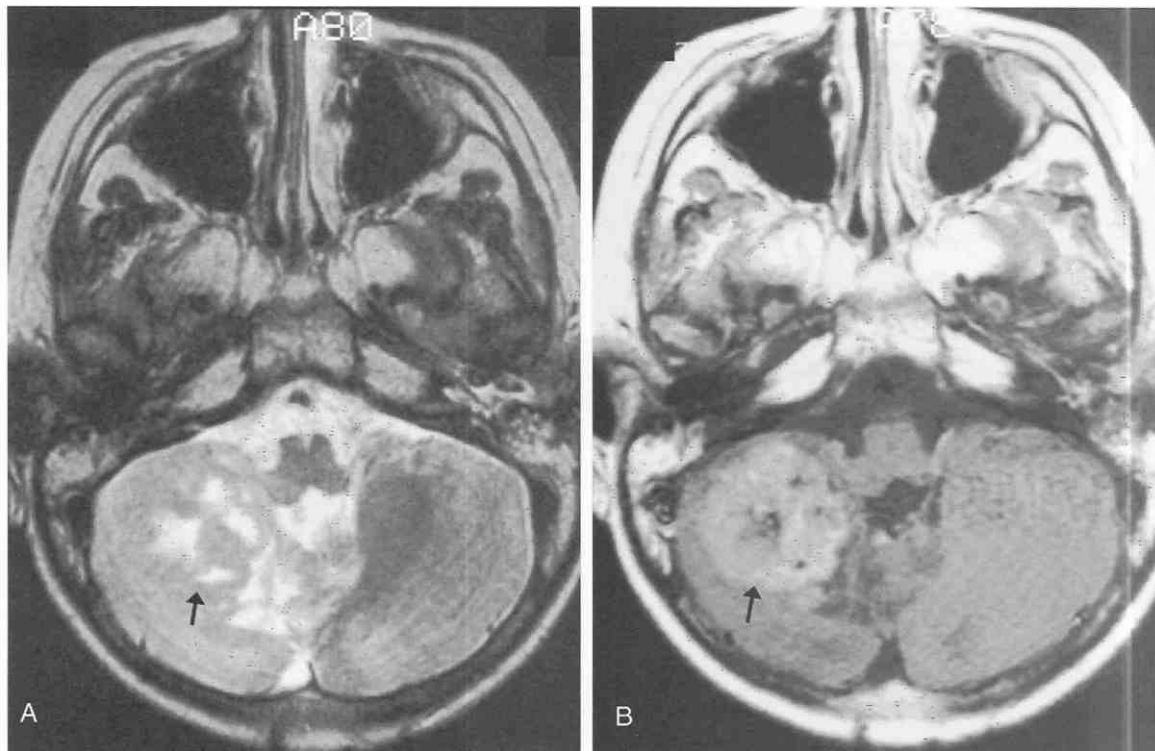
Medulloblastoma of the anteroinferior right cerebellar hemisphere in a 26-year-old patient. *A*, Axial T2-weighted MR image demonstrates a poorly circumscribed mass with a heterogeneous signal pattern in the anteroinferior portion of the right cerebellar hemisphere. Irregular areas of pronounced hyperintensity (arrow) are interspersed in a mildly hyperintense background that likely represents surrounding edema. The tumor extends medially into the inferior vermis. *B*, After intravenous administration of gadolinium, the tumor demonstrates homogeneous contrast enhancement with well circumscribed margins (arrow). Punctate intratumoral hypointensities represent enlarged vascular channels and/or focal calcifications.
